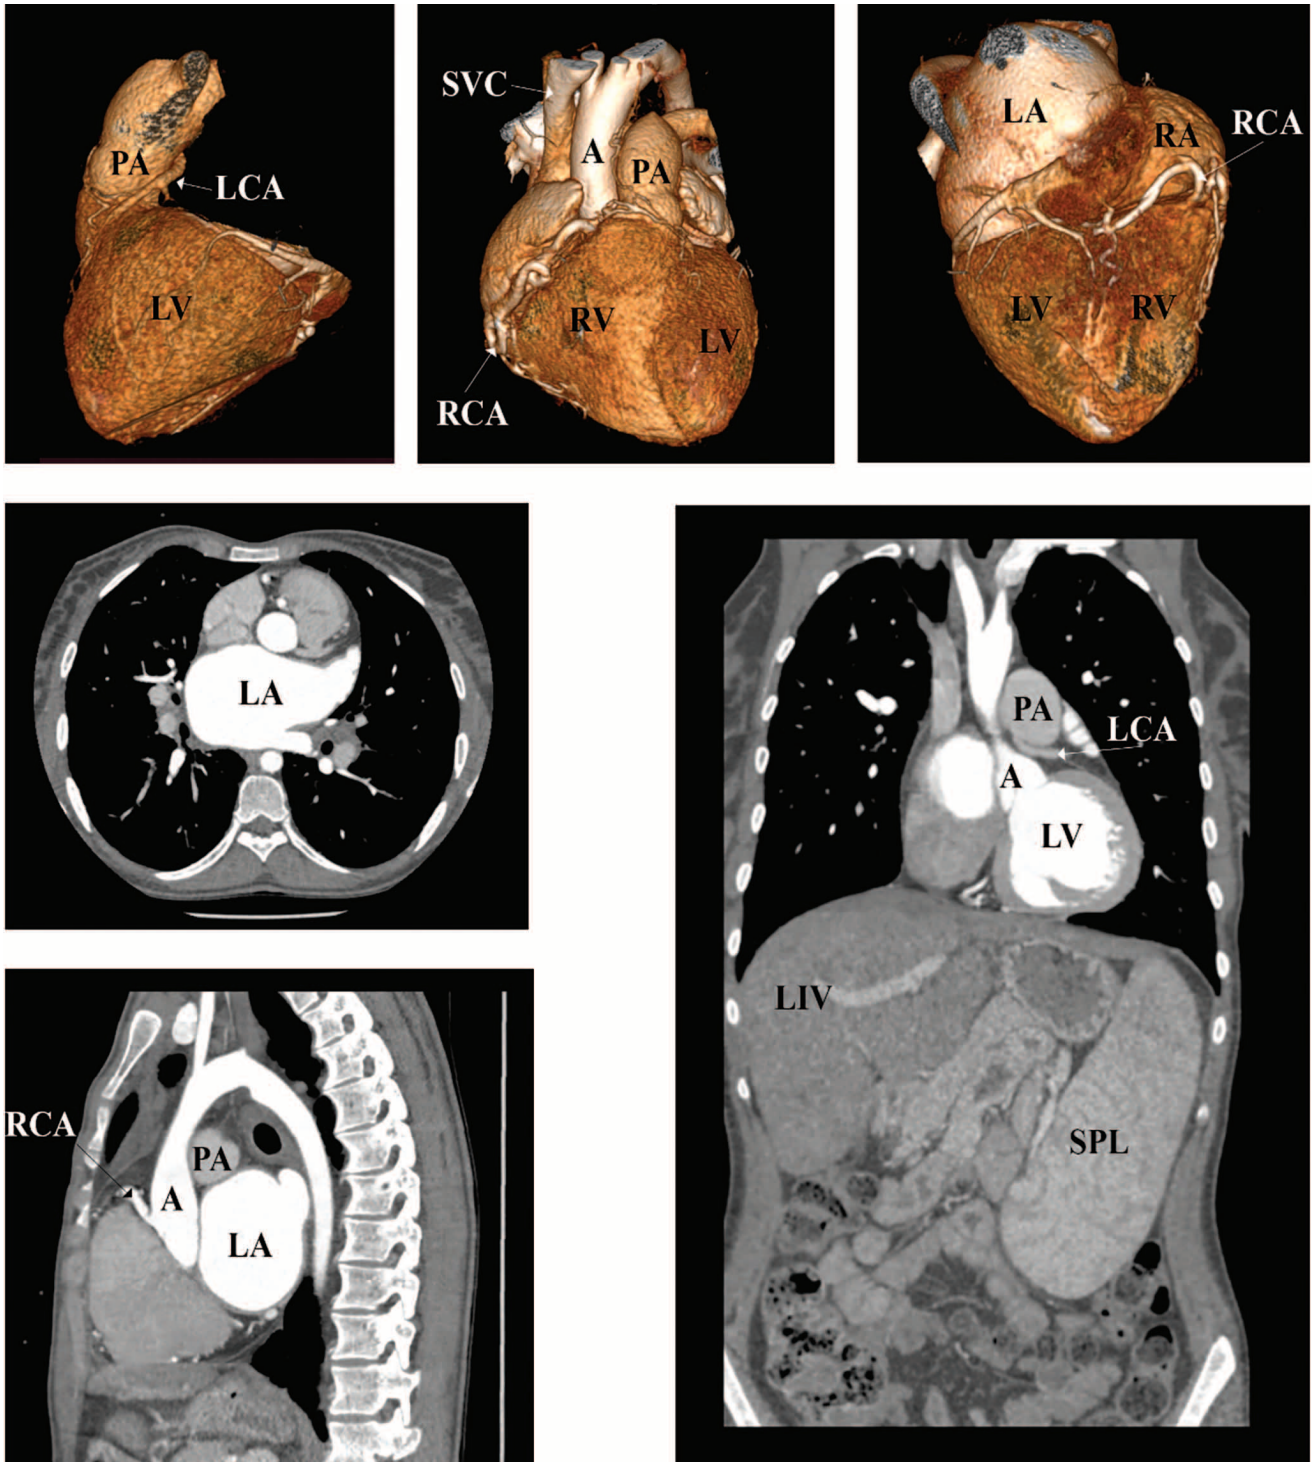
Multi-slice computed tomography of the abdominal cavity and of the chest organs
